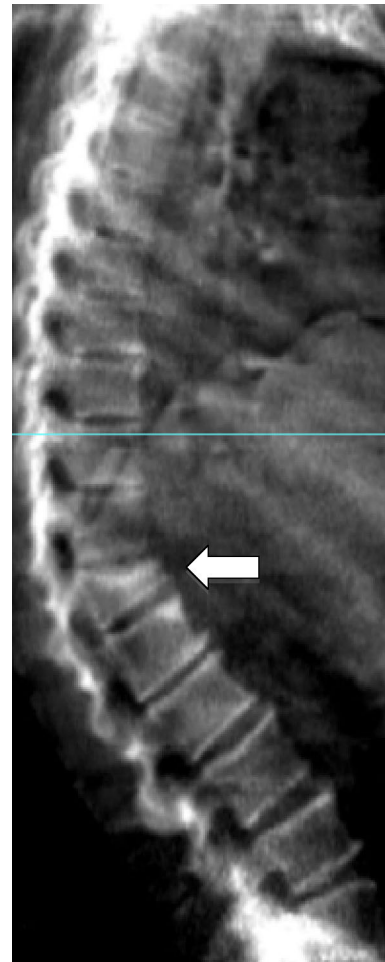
Vertebral fracture assessment by dual-energy X-ray absorptiometry showing a grade 3 vertebral fracture at the level of T12. Identification of a previously unrecognized vertebral fracture may change diagnostic classification, assessment of fracture risk, and treatment decisions [7]
